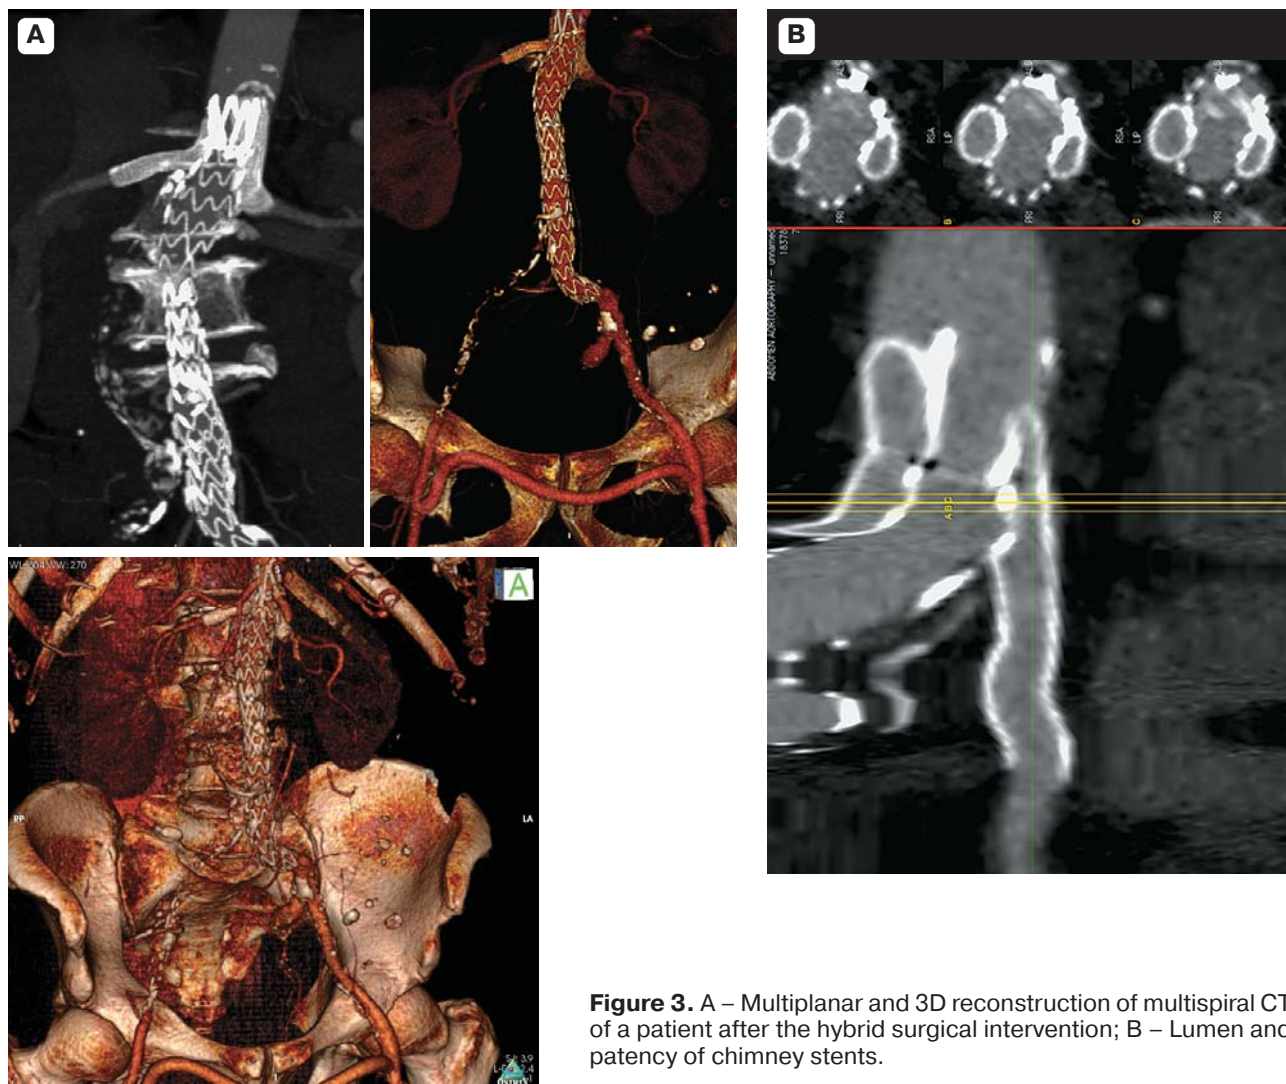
A – Multiplanar and 3D reconstruction of multispiral CT of a patient after the hybrid surgical intervention; B – Lumen and patency of chimney stents.
